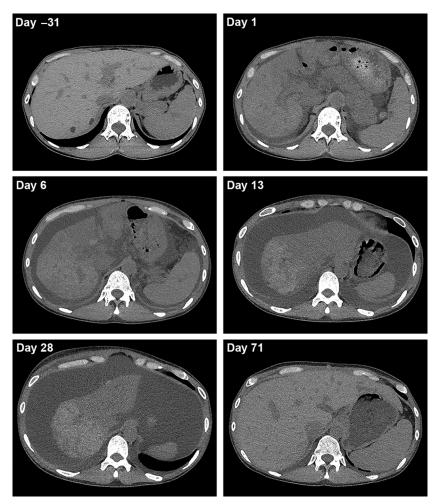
Abdominal computed tomography. The progression of the hepatic atrophy and increase of ascites was observed temporally between day -31 and day 28 and recovered after liver transplantation (day 71).
